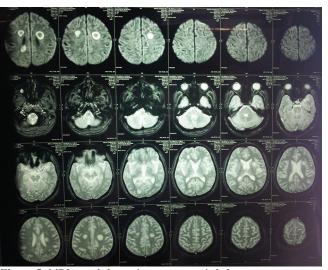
MRI reveals hypertintese concentric halos
